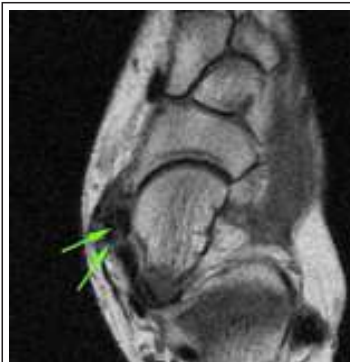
MR image showing Posterior Tibial tendon split.
